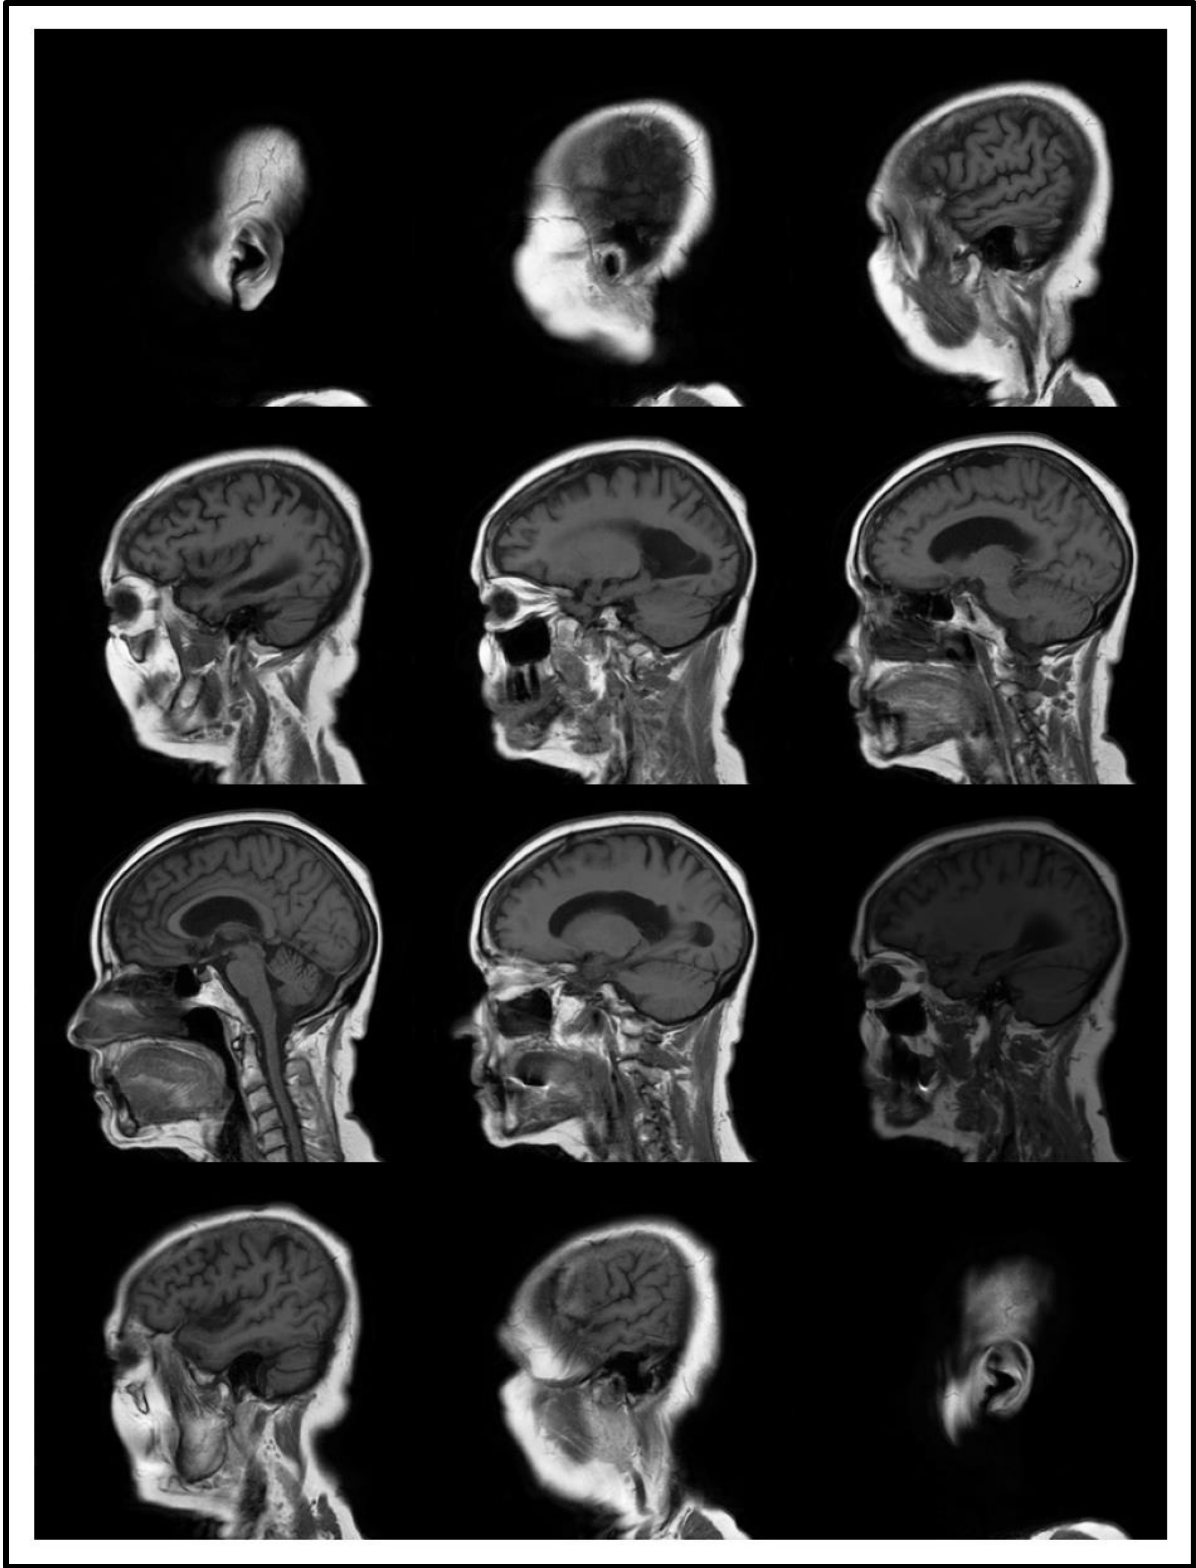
Case 4 MRI Scan Input
